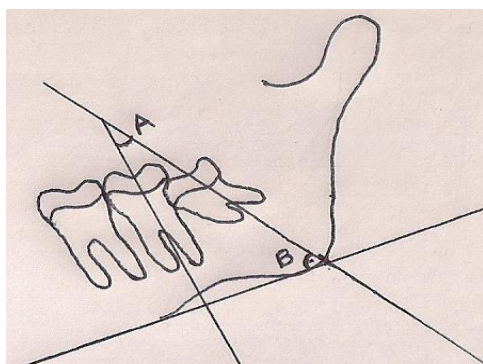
Shows the tracing done on the panoramic radiograph for the measurement of angle A and angle B
